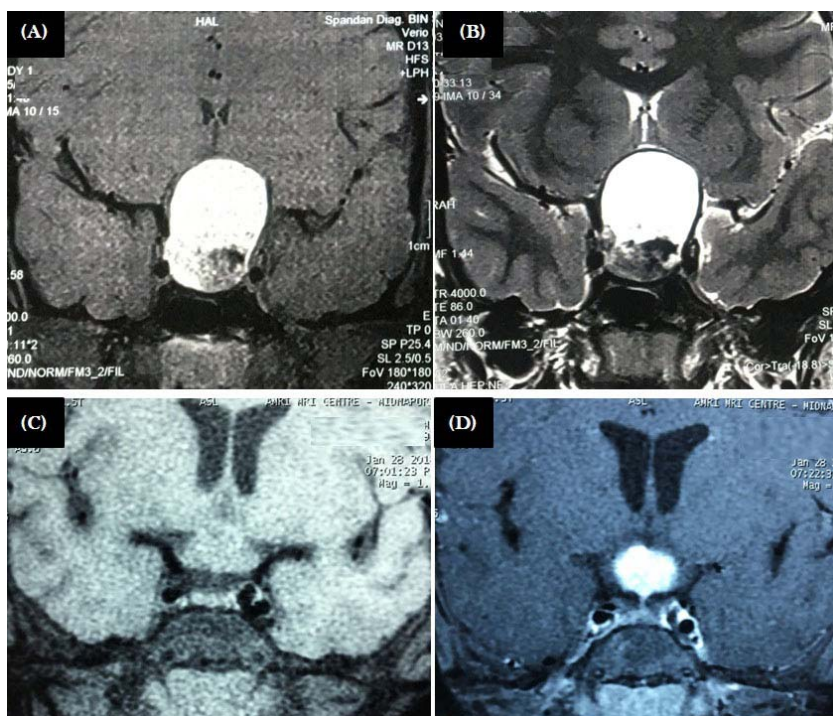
Upper panel: MRI of patients with craniopharyngioma. Mixed solid-cystic lesion with cystic component being hyperintense in both T1 (A) and T2 (B) weighted sequences
